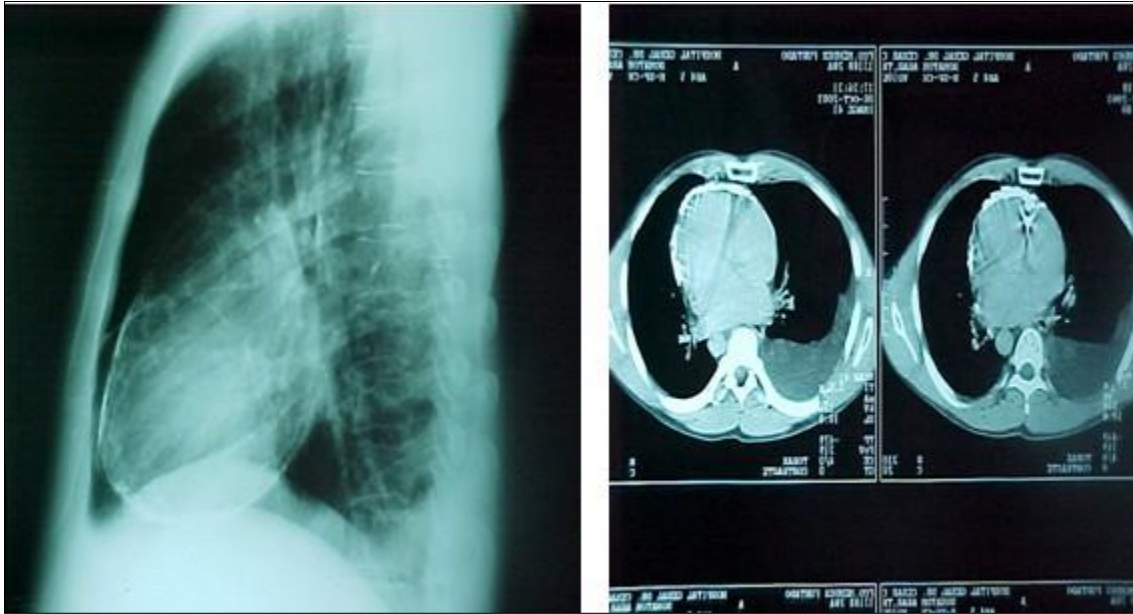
Typical pericardial calcification in the chest X-rays, confirmed by CT.
